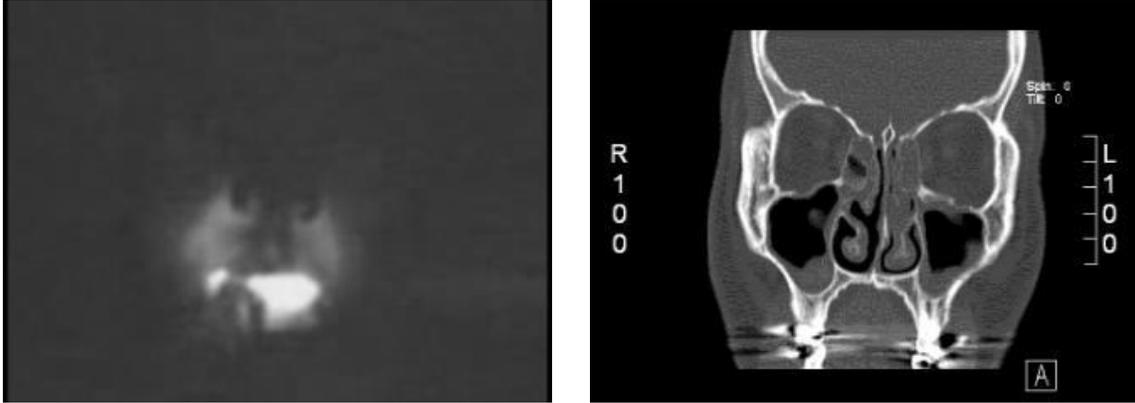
NIR transillumination pattern (left) of 54 year old Asian male with a diagnosis of chronic bilateral maxillary sinusitis with corresponding CT scan (right) revealing significant bilateral mucosal thickening of maxillary sinuses. Note relatively dim transillumination pattern with absence of light penetration into the maxillary sinuses.
